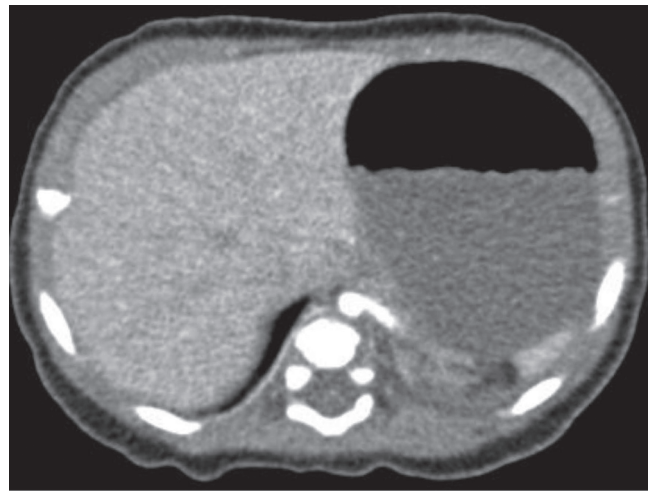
Contrast-enhanced axial CT image.
